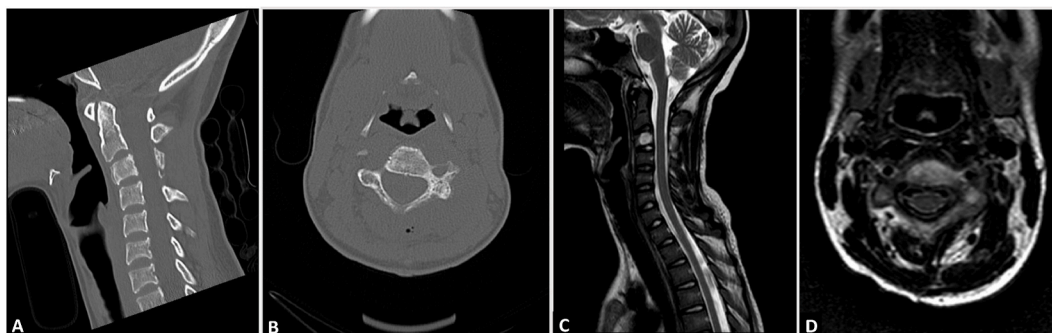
Preoperative examination of EWSA C3 after neo-adjuvant chemotherapy: (A) CT sagittal reconstruction (B) CT Axial view (C) MRI sagittal reconstruction (D) MRI axial view.
